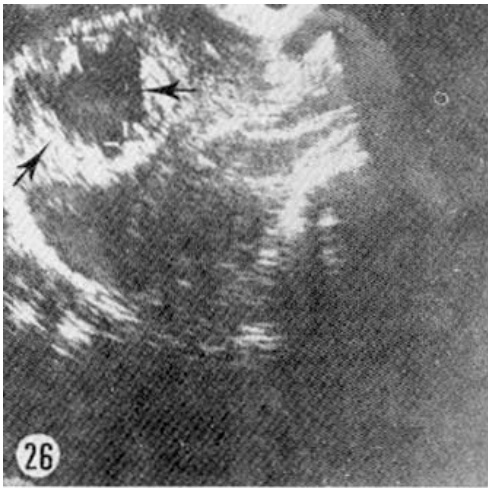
Ultrasonogram of amebic liver abscess. Showing cold areas before (Fig. 26) and after treatment (Fig. 27).
